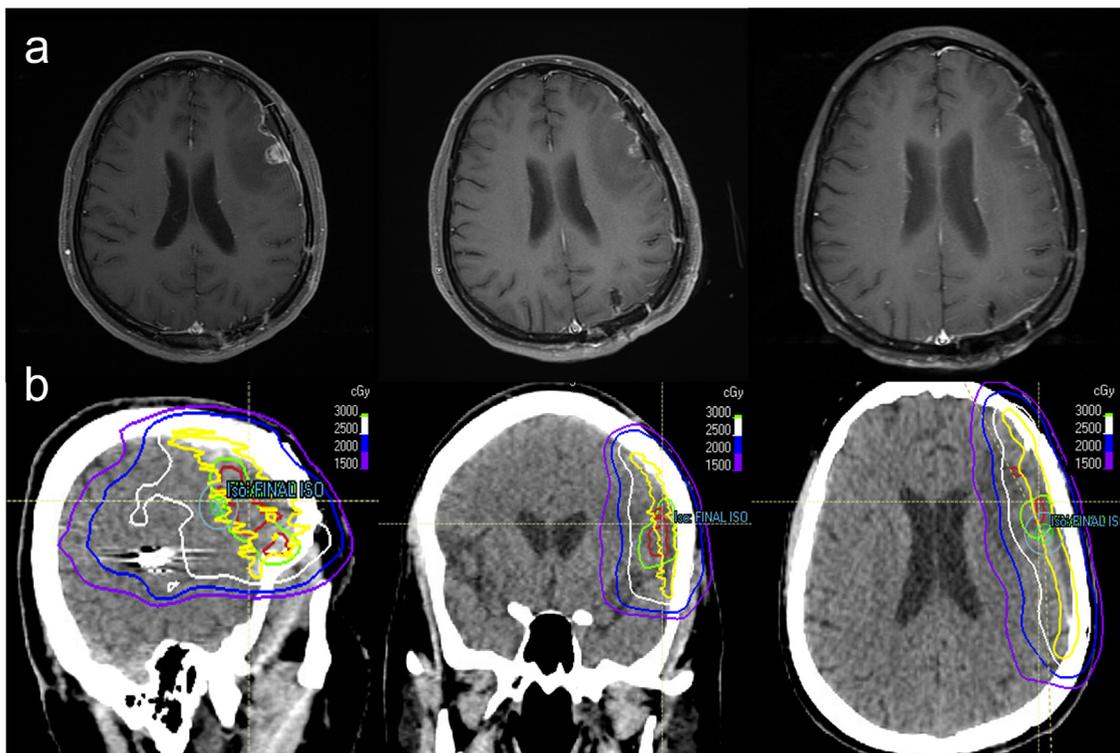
Redo left frontal craniotomy and salvage external beam radiation therapy. (a) Contrasted magnetic resonance imaging from preoperative and 7 months postoperative original surgery (left), immediately postoperative (middle), and 15 months postoperative (right) of redo left frontal craniotomy. (b) Sagittal (left) coronal (middle) and axial (right) non-contrasted computed tomography scans demonstrating salvage external beam radiation for a multifocal marginal recurrence. The gross tumor volume (red) was treated with 30 Gy, and the clinical target volume (yellow) was treated with 25 Gy in 10 fractions.
